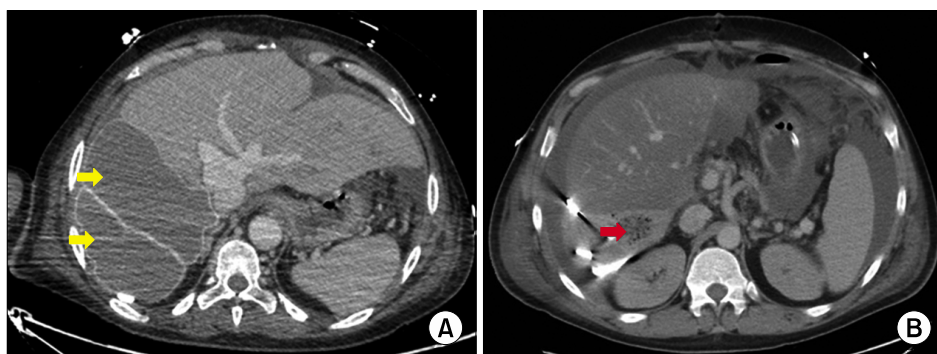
(A) Computed tomography (CT) scan after liver transplantation showing the placement of 2 breast implants (yellow arrow). (B) CT scan after liver transplantation showing the placement of abdominal pads (red arrow).
